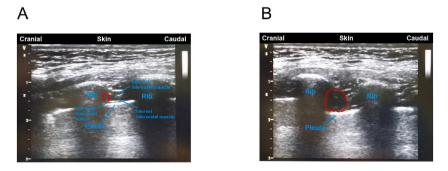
Ultrasound scans of the intercostal nerve area before and after ICNB.
